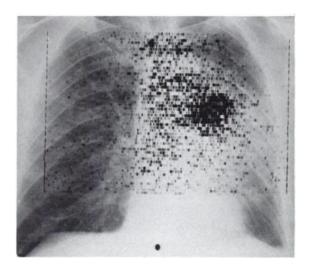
Anterior ⁴⁷Ga-citrate scan taken 5 days following intravenous injection shows accumulation in region of tumor mass seen on chest x-ray.
